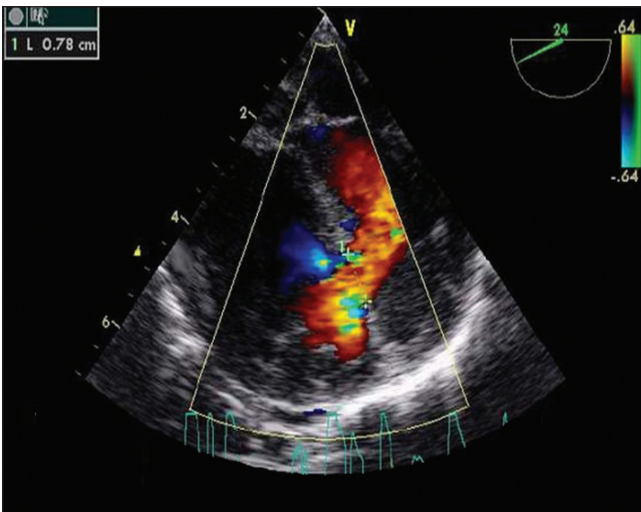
Large ventricular septal defect in echocardiography
